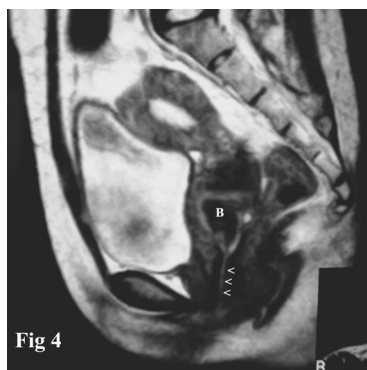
Transverse vaginal septum in a 22-year-old woman with scanty menstruation and cyclic pelvic pain. Sagittal T2-weighted fast SE image (TR/TE, 4500/120) showed normal cervix and uterus. There was a low intensity mass in the upper portion of the vagina, just above the septum. The signal intensity of the mass was compatible with old blood block (B). The distal part of vagina was seen as thin string of relative high signal intensity (arrowheads)
